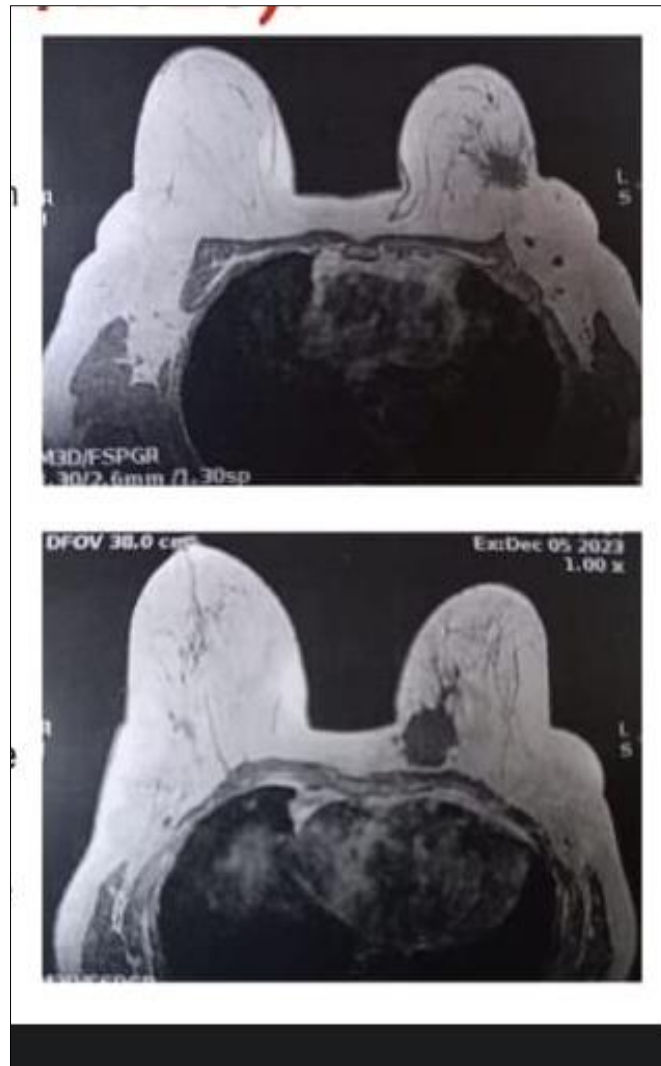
MRI showing two lesions on the left breast
